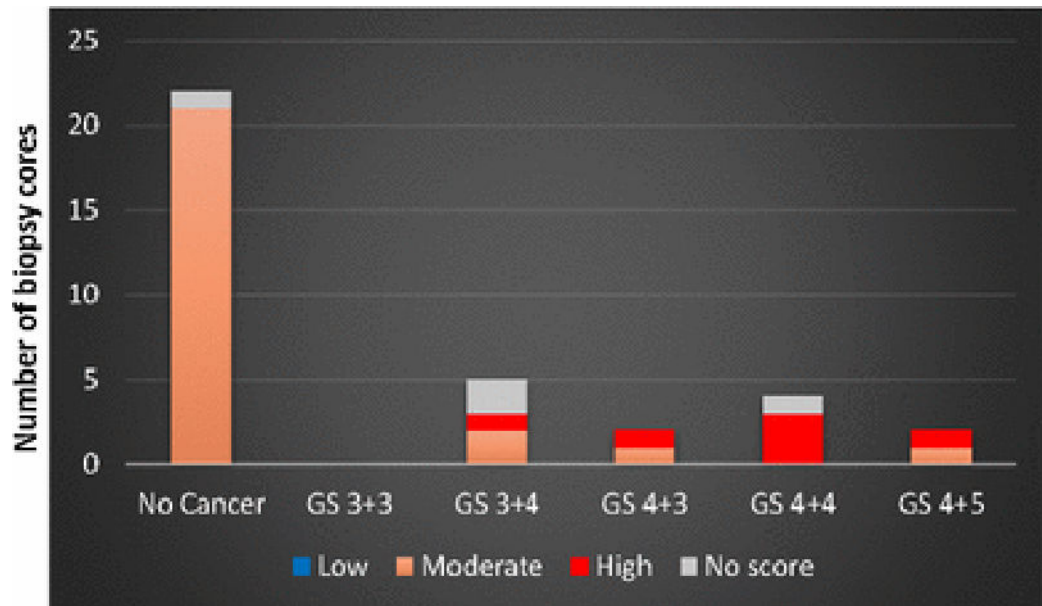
Gleason score distribution and MRI grades of the 35 biopsy cores of data set A used for training a model to characterize cancerous versus non-cancerous cores.
